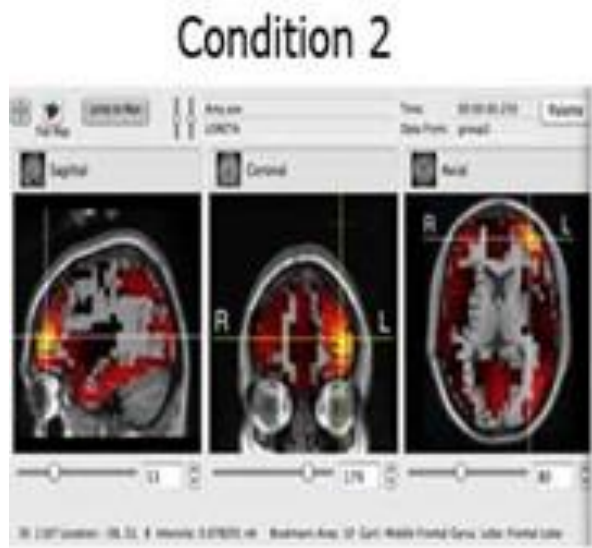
Example of brain activity in MRI during the visual task
